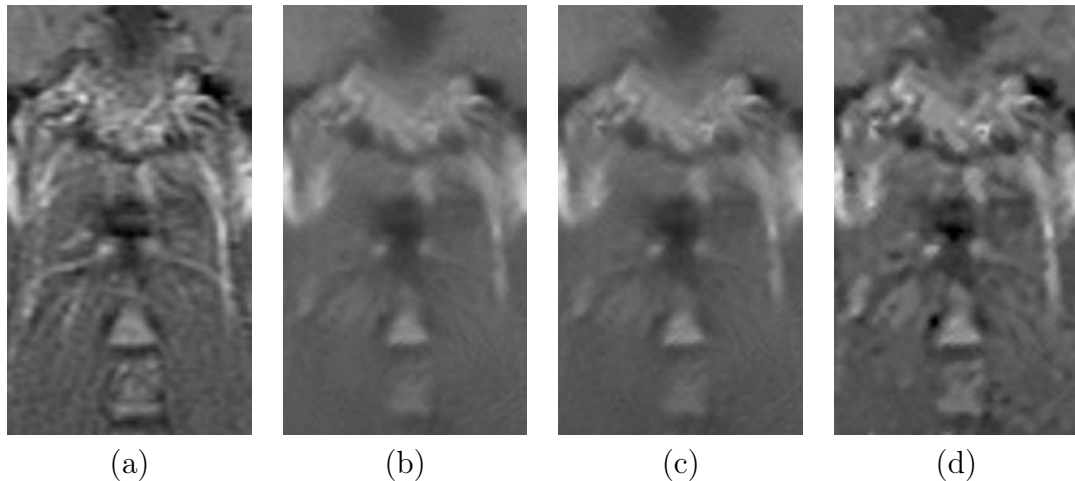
Zoomed in portion of the real MR image 1: (a) noise free, (b) NLM [46], (c) UNLM [42], and (d) PCNNNI_IUNLM.
